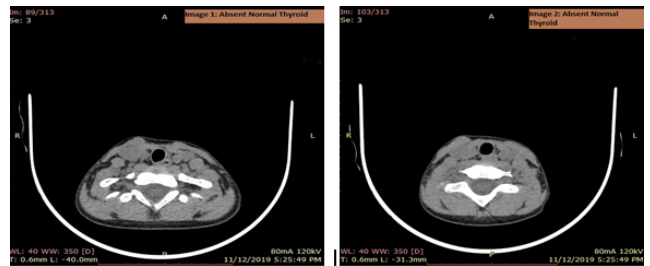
Showing absent thyroid gland on CT scan
